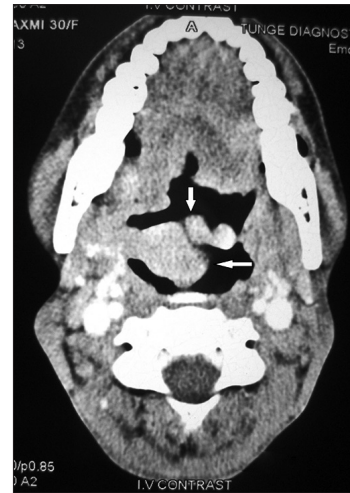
Computed tomography axial view showing soft tissue mass (marked by arrow) arising from soft palate reaching up to the posterior pharyngeal wall causing obliteration of nasopharyngeal and oropharyngeal airway
